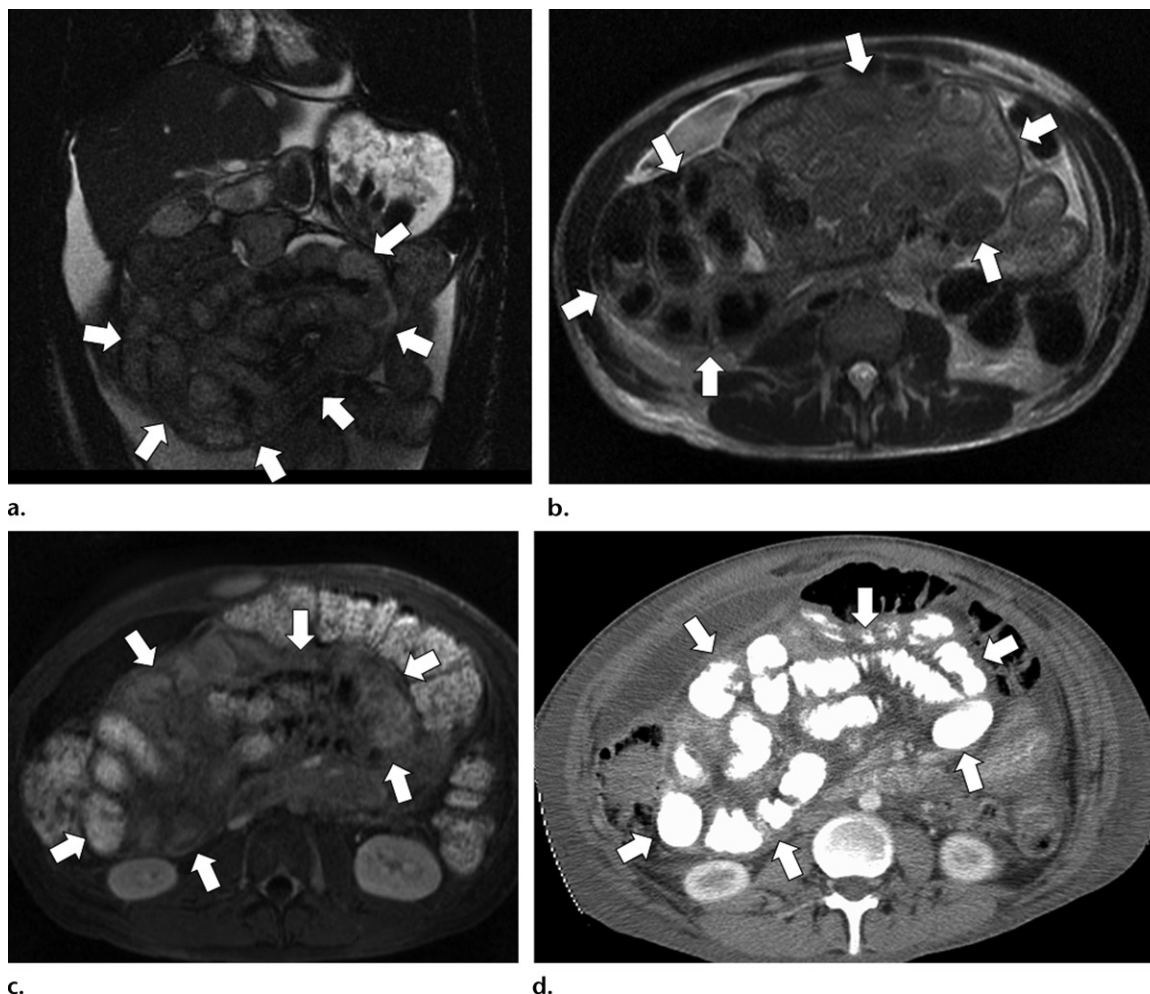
EPS in a 26-year-old man with vague abdominal symptoms who was receiving therapy with long-term dialysis (same patient as shown in Fig 4). (a–c) Coronal balanced steady-state precession MR image (a), axial single-shot fast spin-echo MR image (b), and axial gadolinium-enhanced T1-weighted gradient-echo MR image (c) show clustered small-bowel loops and the encasing thickened peritoneal membrane (arrows). (d) Axial contrast-enhanced CT image obtained after administration of oral contrast material helps confirm these findings of EPS (arrows).
